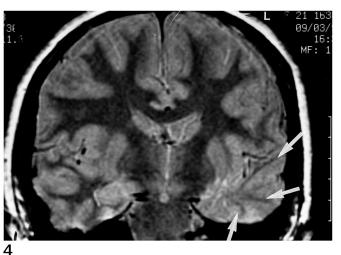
Fast spin-echo proton-density coronal MR image (2840/17 effective/1, 256 \times 256 matrix) demonstrates high signal, consistent with gliosis in the white matter of all gyri (*arrows*) in the left anterior temporal lobe after a trans-Sylvian AH.
